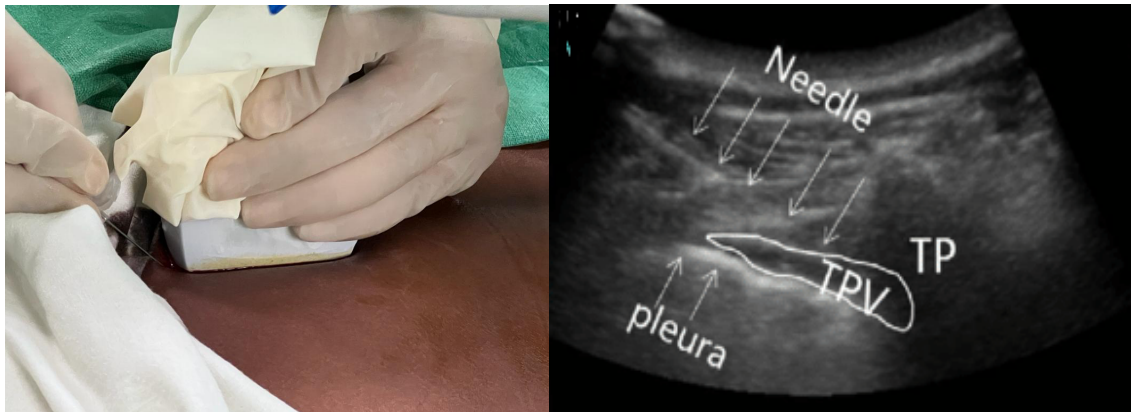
Ultrasound guided paravertebral block.
